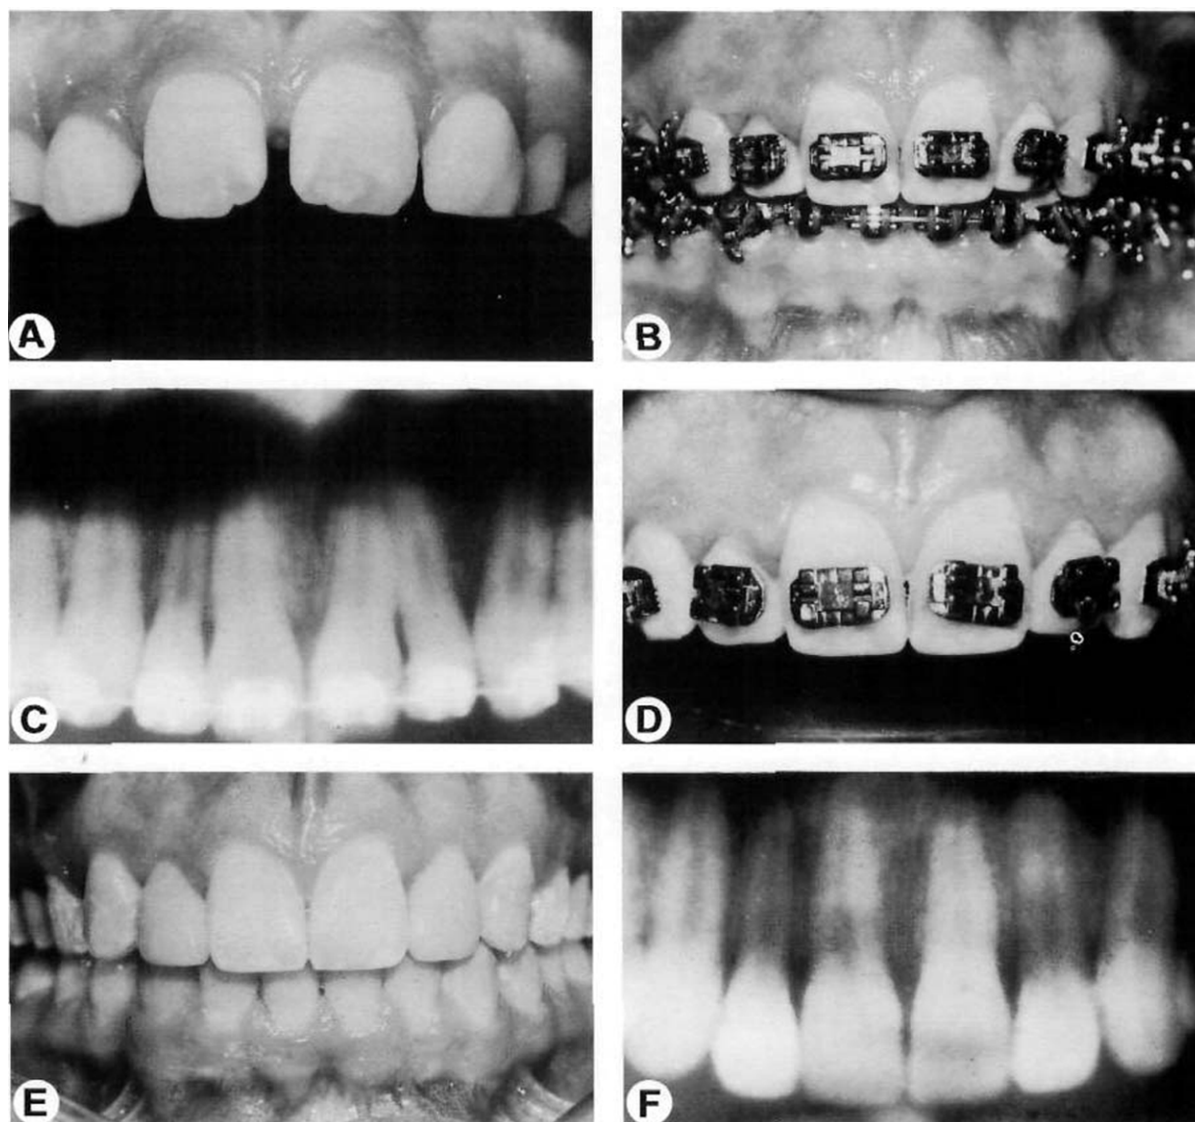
This patient had peg-shaped maxillary lateral incisors. These teeth had been restored before orthodontic therapy (A). During orthodontic finishing, (B) a progress panoramic radiograph was made (C). The radiograph showed that the roots of the teeth did not reflect the position of the incisal edges of the crowns. The teeth were rebracketed (D) and the roots were aligned properly (F). By aligning the roots properly, the esthetic appearance of the restorations could be enhanced (E).
